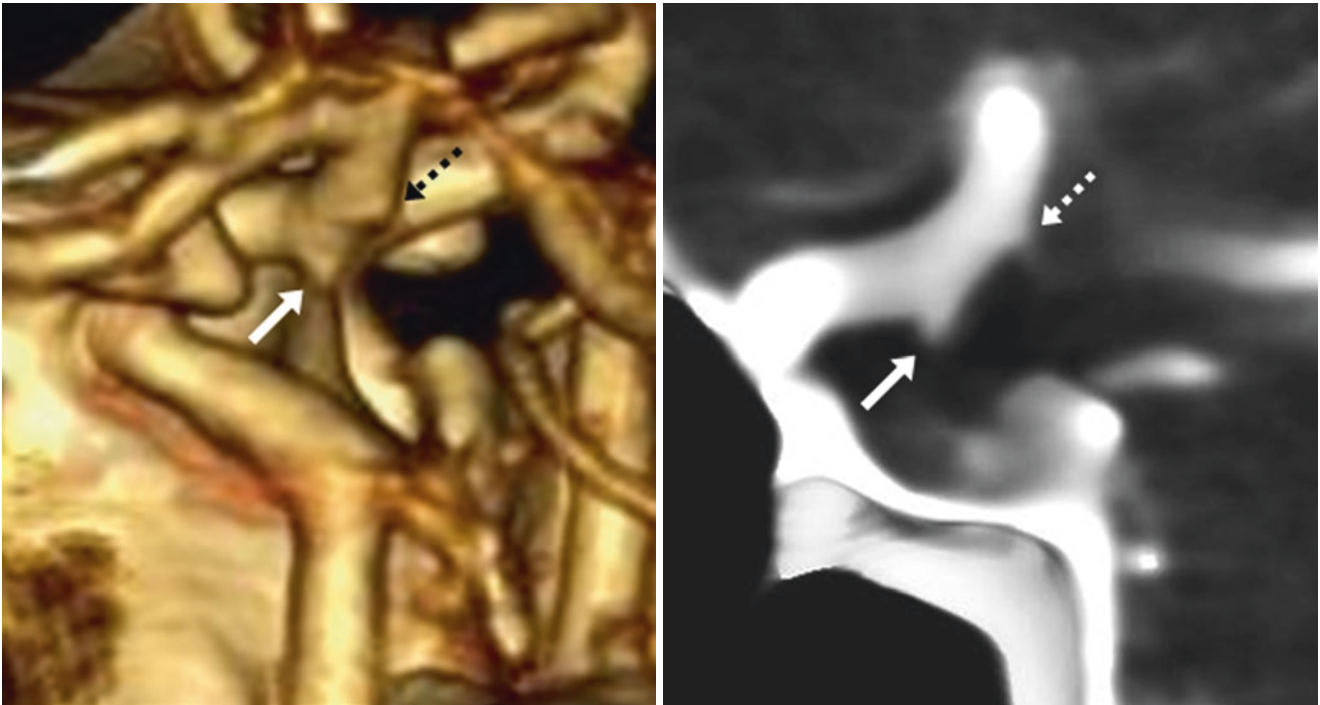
In this 49-year-old, a VR CTA lateral view (*left*) depicts a tiny (<2 mm) infundibular outpouching (*arrows*) arising at the origin of the PcoA. A vessel arises from the apex, as seen on a 4-mm MPR (*arrows, right*). Also note a tiny anterior choroidal-origin infundibulum (*dotted arrows*)
